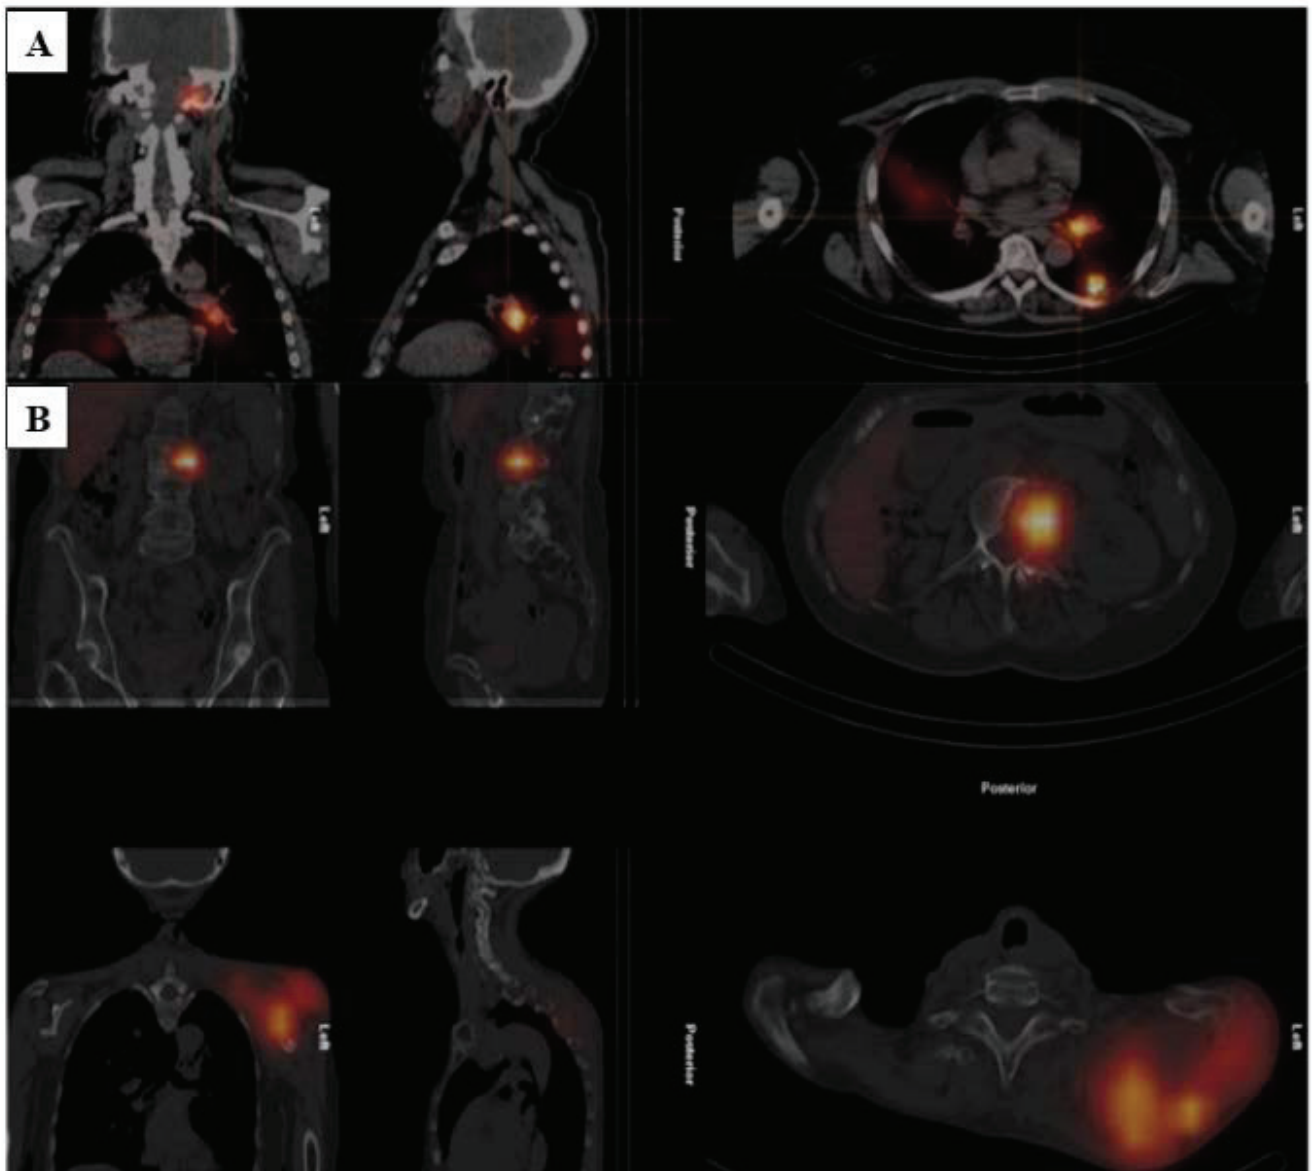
Theranostic SPECT/CT 3 days after a after a standard treatment of 3,7 GBq Iodine-131. Scans are superimposed on a low dose CT used for attenuation and anatomic location of the SPECT scan.
